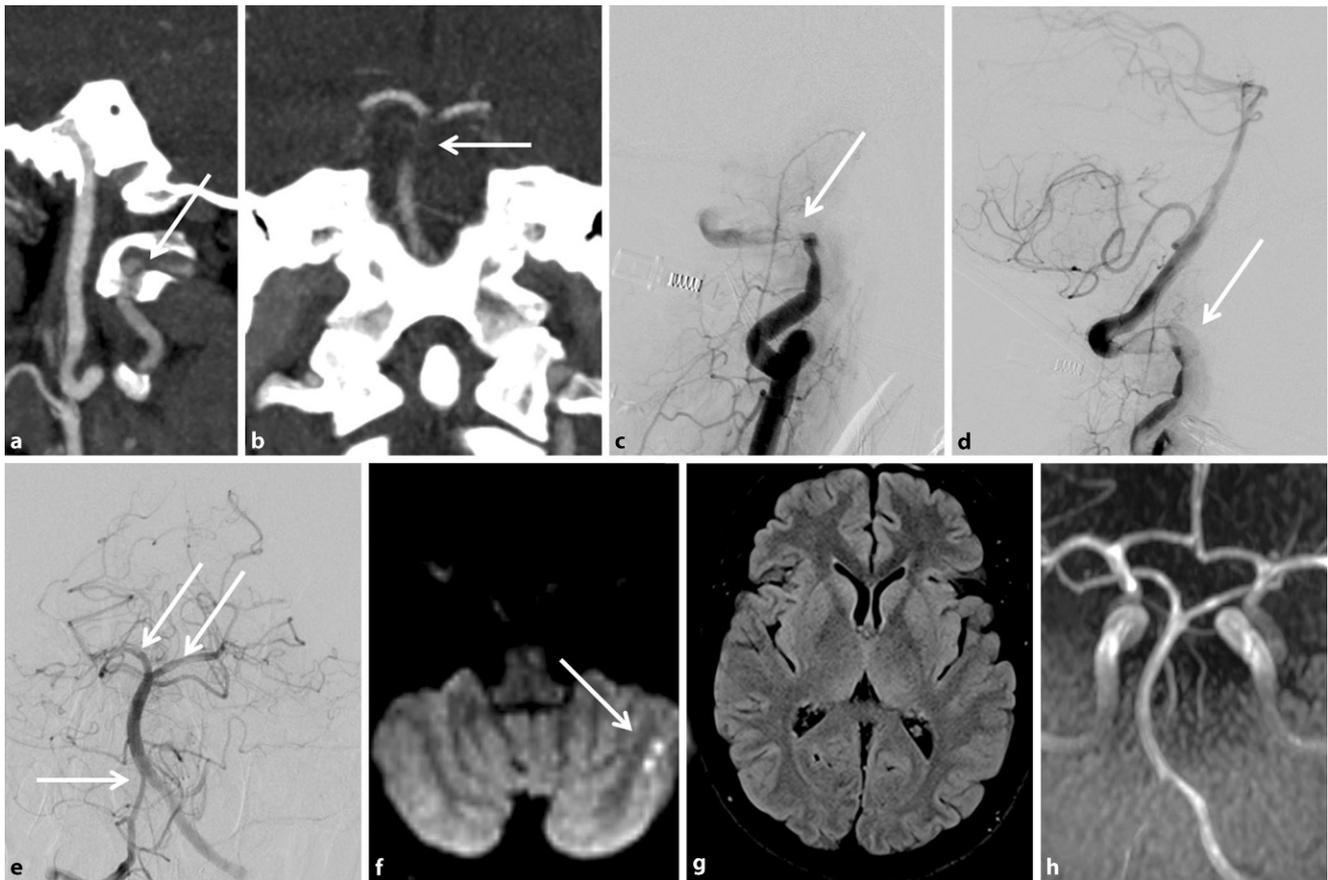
36-year-old male with spontaneous nuchal pain and intermittent neurological symptoms, deteriorating to coma in the emergency room. a CTA shows a high-grade stenosis of the left dominant vertebral artery V3 segment due to dissection (*arrow*) and b an embolic distal basilar artery occlusion (*arrow*). c Lateral digital subtraction angiography (DSA) shows the dissection in V3/VA (*arrow*) and impaired filling of the artery. d After passing the dissection with a 6F SOFIA catheter under applying of manual aspiration and an additional ADAPT thrombectomy maneuver, complete recanalization could be achieved, while the dissected V3 segment was left untreated (*arrow*). The patient was heparinized and given aspirin 100 mg/d permanently. e DSA in posterior-anterior view after injection of the right VA shows complete recanalization of the BA and posterior cerebral arteries (PCA) (*arrows*). f Follow-up MRI after 24 h shows minimal cerebellar infarctions in the diffusion weighted image (*arrow*), while the cerebrum did not exhibit additional ischemia (g). h Time of flight (TOF) angiography shows full patency of the BA and PCAs. The patient woke up neurologically intact, experienced a short TIA 1 h prior to the MRI with complete resolution of symptoms and has since then been asymptomatic (NIHSS 0, mRS 0)
